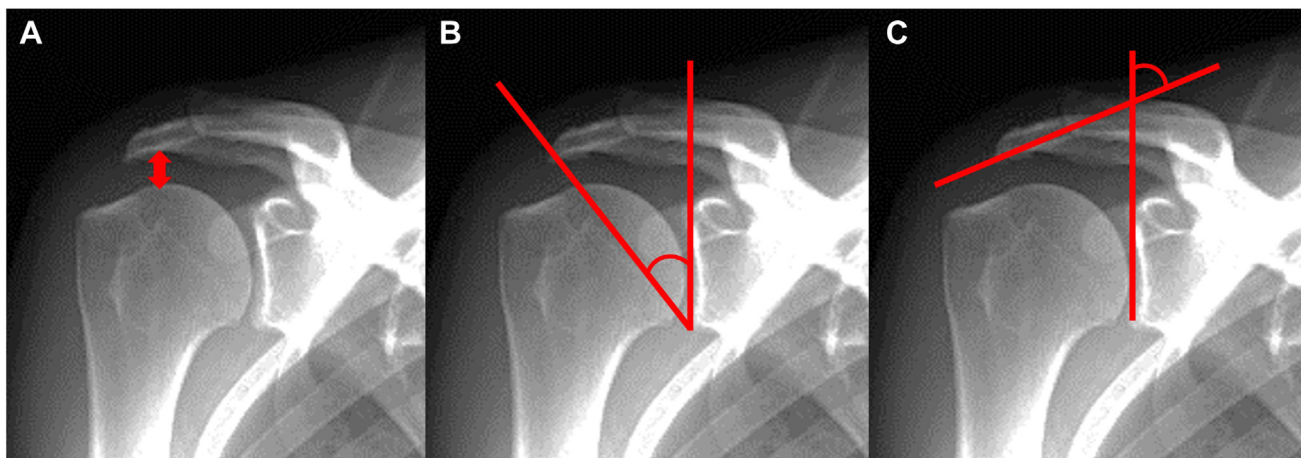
Standard anteroposterior radiographs of the AHD, CSA, and LAA. (A) The AHD is defined as the distance from the inferior surface of the acromion to the apex of the humeral head. (B) The CSA is defined as the angle between a line intersecting the superior and inferior edges of the glenoid fossa and another line intersecting the inferior edge of the glenoid with the most inferolateral edge of the acromion. (C) The LAA is defined as the intersection of 2 lines representing the glenoid cavity and the inferior surface of the acromion. AHD, acromiohumeral distance; CSA, critical shoulder angle; LAA, lateral acromial angle.
